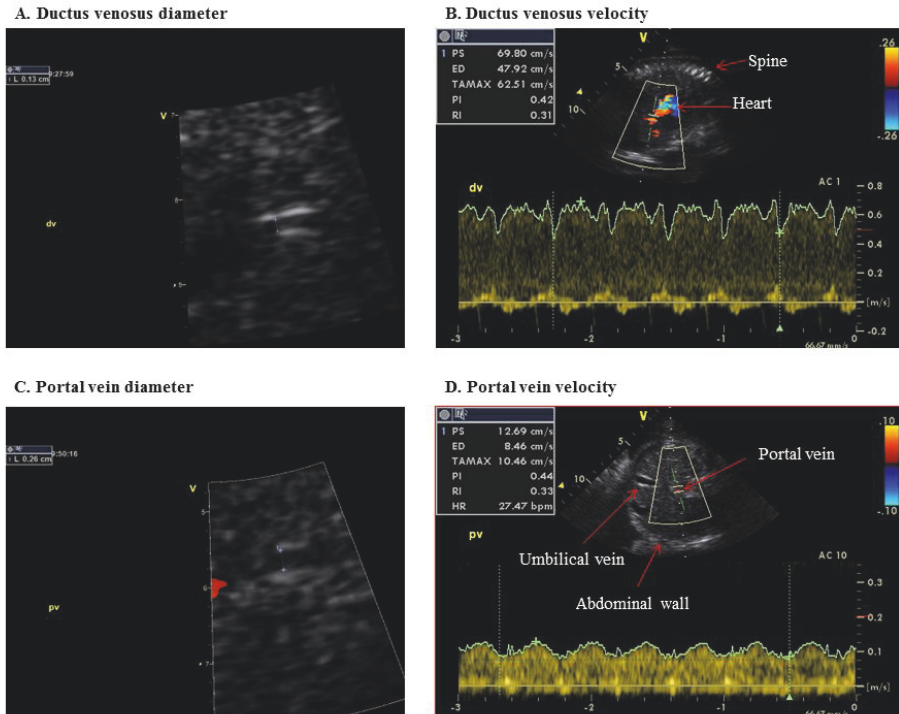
A and C. The inner vessel diameters in ductus venosus and portal vein respectively, measured at least three times, in magnified images with the color Doppler turned off. B. Sagittal view angled from the neck towards the flow direction of ductus venosus. D. Portal vein velocity with a typical pulsatile flow pattern
